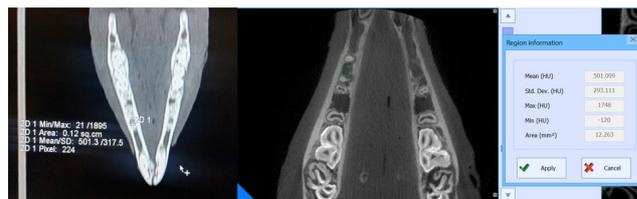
Placement of the regions of interest (ROI) in the mandibular arch of sample I in the axial section of the computed tomography (CT) scan (left) and in the corresponding axial section of the cone-beam computed tomography (CBCT) scan (right)
